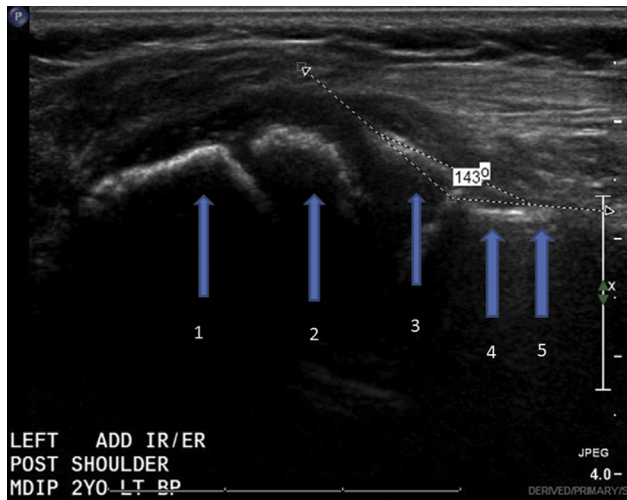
Ultrasound image of posterior shoulder subluxation. Arrow 1: ossified humeral diaphysis and metaphysis; arrow 2: partially ossified humeral head; arrow 3: cartilaginous glenoid labrum; arrow 4: spino-glenoid notch (contains suprascapular nerve); arrow 5: scapula. The α angle is 37° ($180^\circ - 143^\circ = 37^\circ$).
